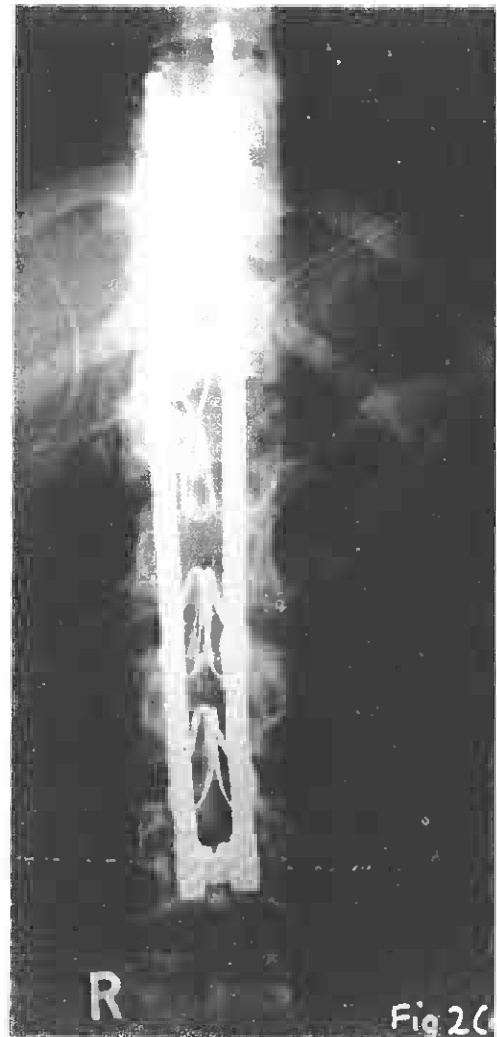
(d) post-operative Radiographs of L.K.K.
